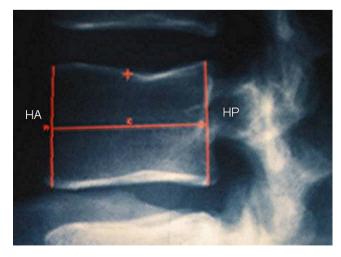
Radiographic morphometry measurement of anterior height (AH) and posterior height (PH).
